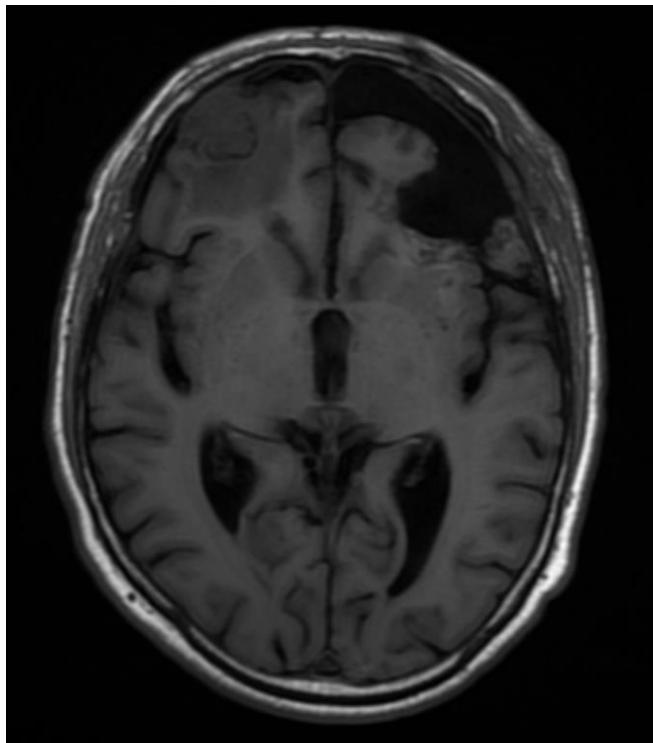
Post surgery T1 Flair brain MRI.
